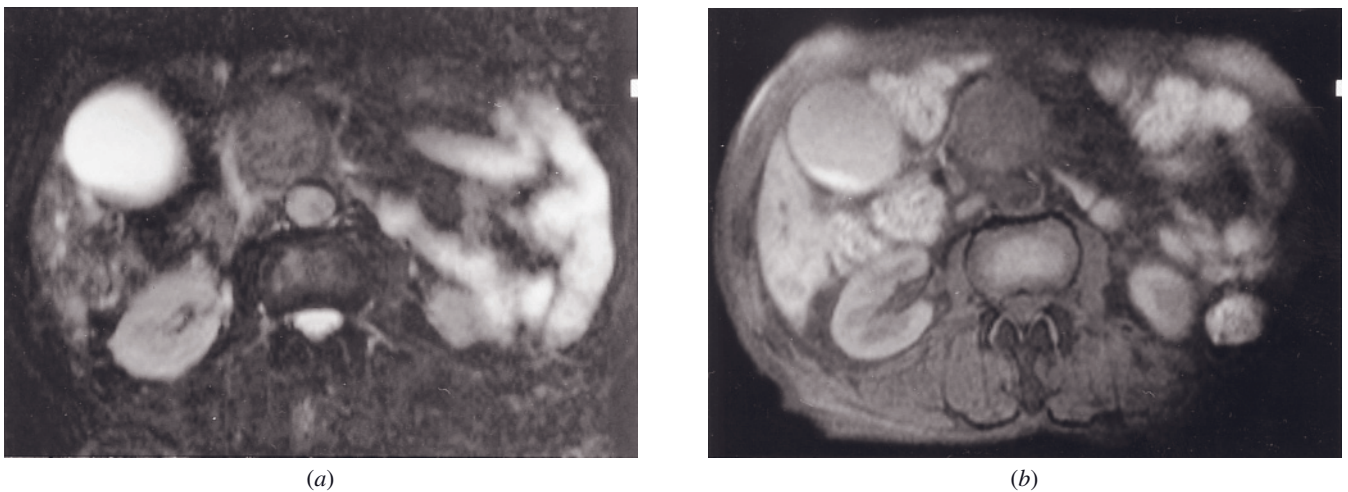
Large pancreatic cancer arising in the head. T2-weighted fat-suppressed SS-ETSE (a), T1-weighted fat-suppressed spin-echo (b), immediate postgadolinium T1-weighted SGE (c), and interstitial-phase gadolinium-enhanced T1-weighted
